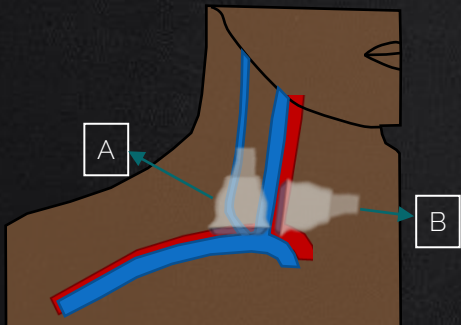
internal jugular ultrasound. IJV = internal jugular vein; SCA = subclavian artery; CCA = common carotid artery.
